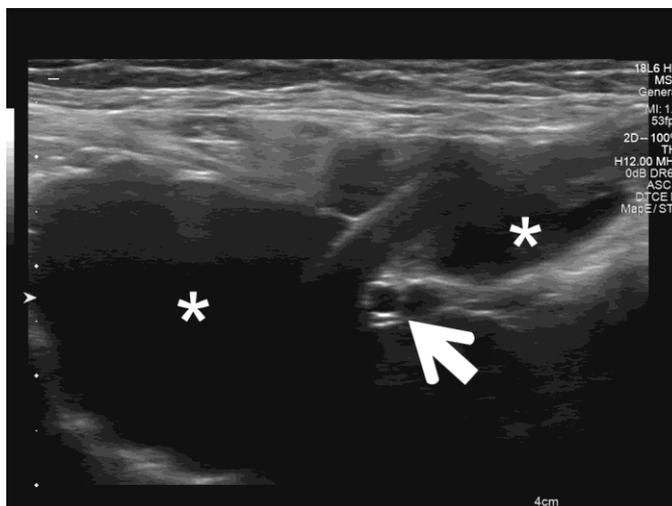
Ultrasonographic examination revealed a well-defined, hourglass-shaped anechoic cystic swelling (stars) within the inguinal canal adjacent to the right common iliac artery (arrow)
